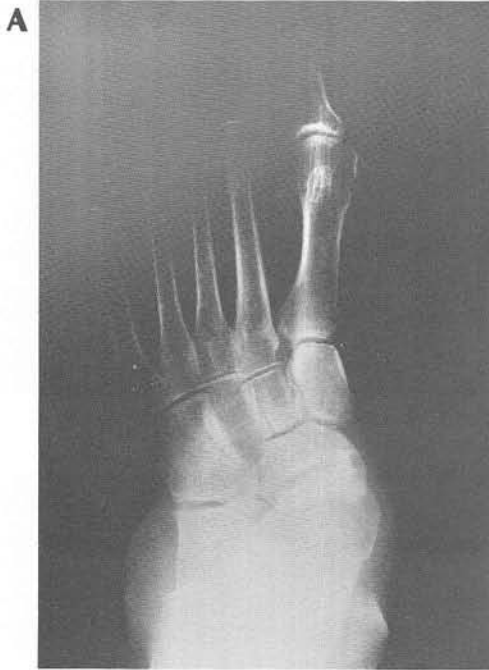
D. Dorsoplantar radiograph following triple arthrodesis and first metatarsal osteotomy.
